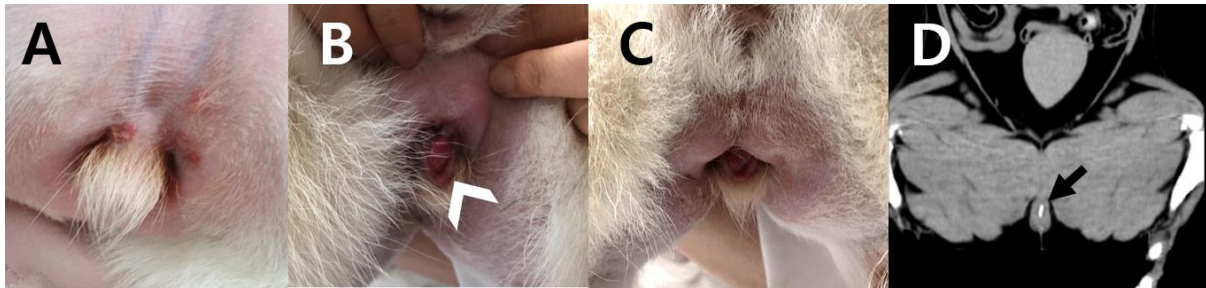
Preoperative examination of the perivulvar region. (A) Perivulvar dermal ulceration on the ventral perivulvar region. (B) The hypertrophied clitoris protruding from the vagina (white arrowhead). A solid material object is palpated on the ventral clitoral side. (C) Recessed vulva partially covered by excessive perivulvar skin folds. Mucopurulent discharge was stuck in the folds. (D) CT scan of the patient with clitoral hypertrophy containing os clitoris. A hyperattenuating curvilinear structure was observed in the clitoris (black arrows).
